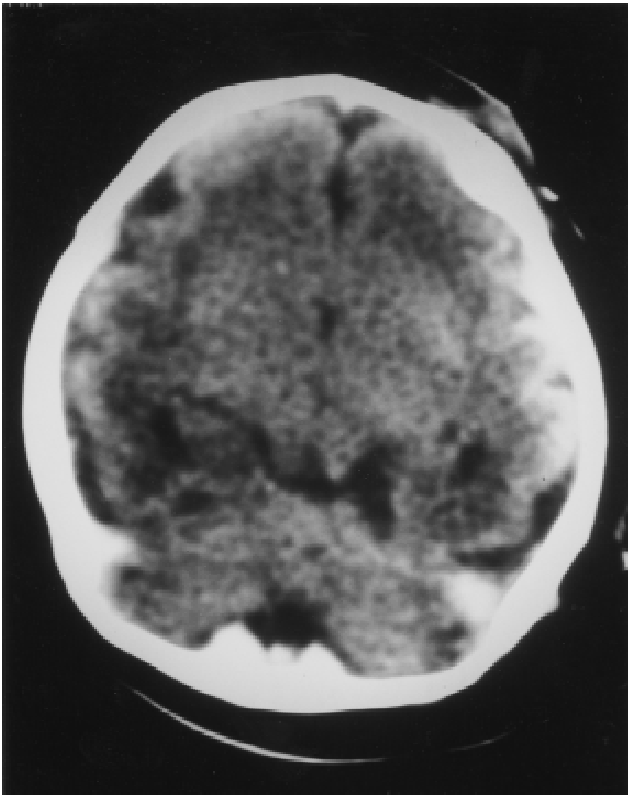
CT scan of the head of the proposita, showing (left) the absence of the corpus callosum and pachygyria and (right), a large dorsal left-sided cerebral cyst.
